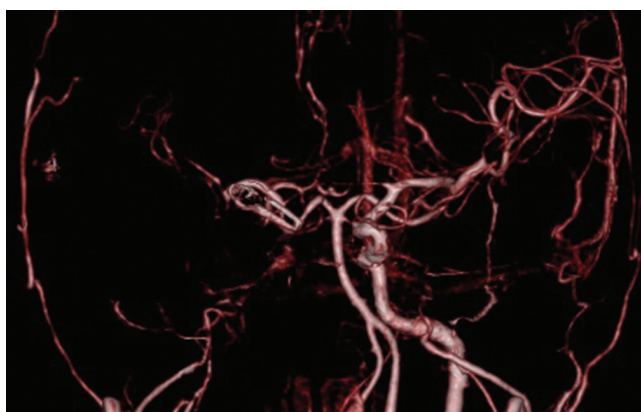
The computed tomography after the first operation showing no right internal carotid artery and aneurysm.
